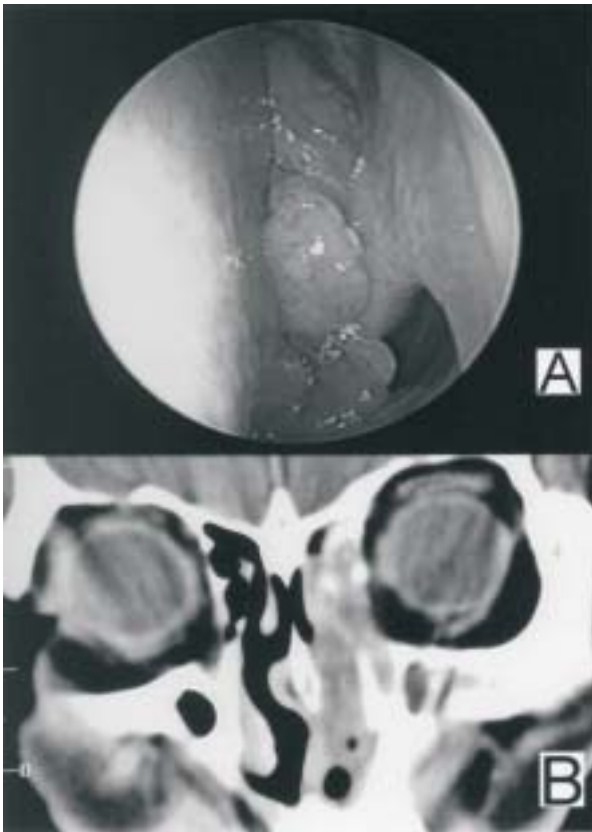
(A) A fleshy, polypoid tumor filled the left nasal cavity. (B) Computed tomography showed soft tissue mass in left nasal cavity. Large part of defect in left lamina papyracea without orbital content invasion by tumor was revealed.
